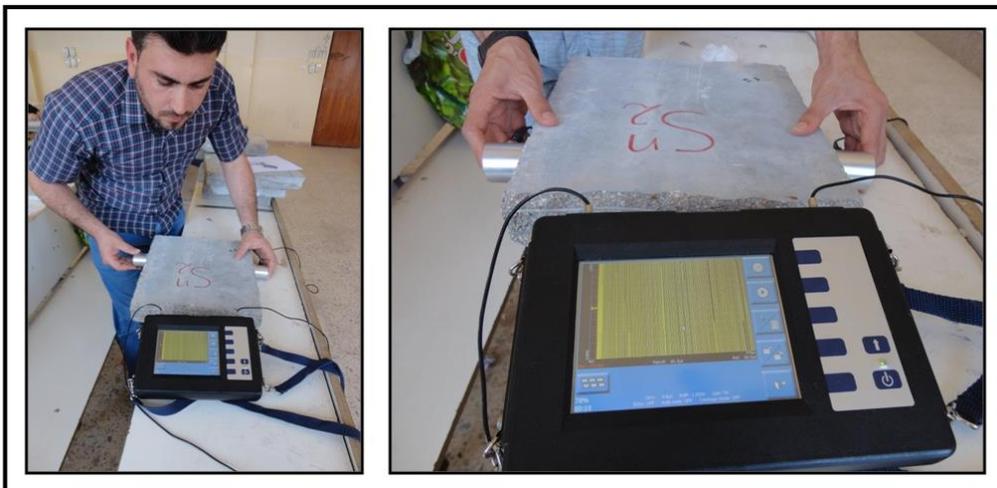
Ultrasonic Pulse Velocity (UPV) Test
